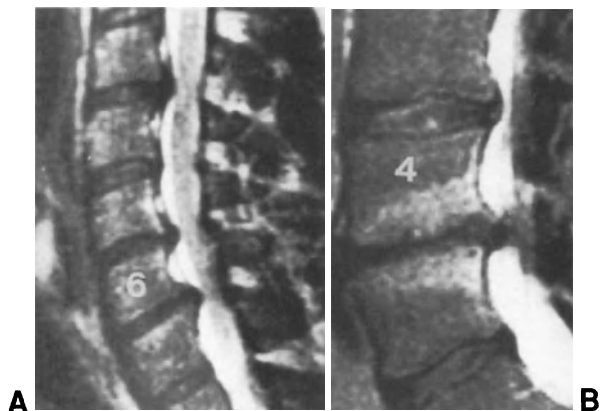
MR sequences of a patient with asymptomatic herniations in the cervical spine and a symptomatic herniation at L4-L5 level. (A) Turbo spin-echo T2-weighted sagittal image showing disc herniation at C3-C4 and C5-C6 levels and stenosis at C6-C7 level. (B) Turbo spin-echo T2-weighted sagittal image revealing stenosis of the spinal canal and disc herniation at L4-L5 level.
